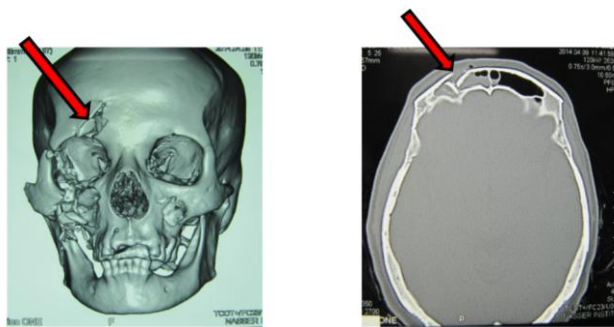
a) Preoperative 3D CT showing a right side anterior table fracture of the frontal sinus with comminuted right ZMC and orbital floor Fracture; b) An axial cut CT showing the unilateral displaced anterior table fracture of the right frontal sinus cavity
